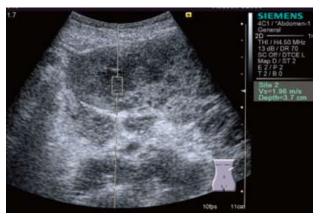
Measurements of stiffness with virtual touch tissue quantification (VTTQ) were made at a depth of 3-4 cm from the body surface under B-mode ultrasonographic guidance.
